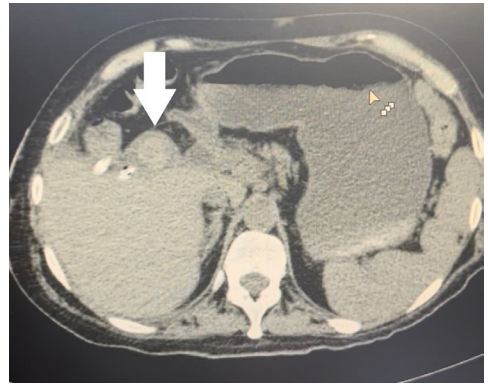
CT scan of the abdomen showing hyperdense content (white arrow) in the jejunal loop of the digestive tract.
